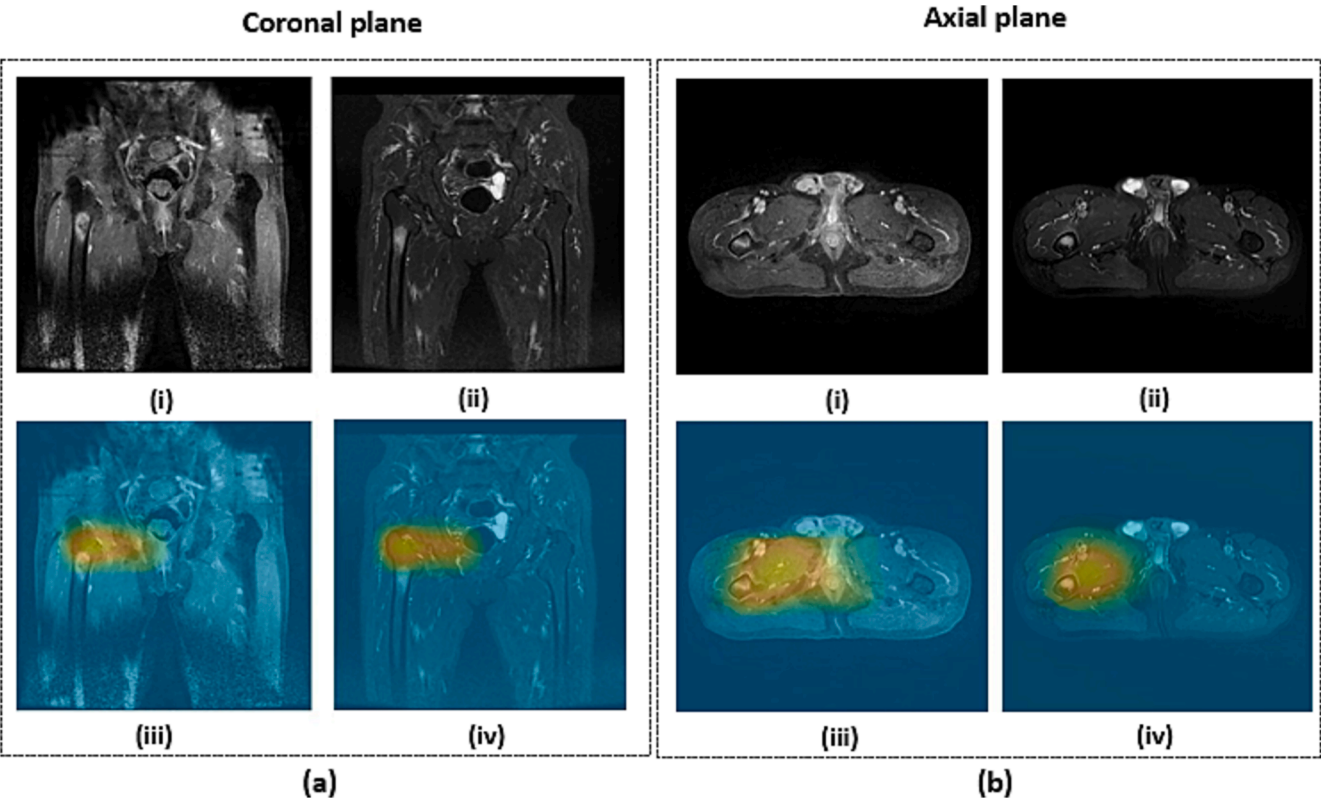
MRI scans of the femur that pertain to (a) coronal plane and (b) axial plane, depicting (i) malignant tumour—T1 FS with weighted image; (ii) benign tumour—T2 weighted image; and (iii, iv) corresponding class activation maps.
